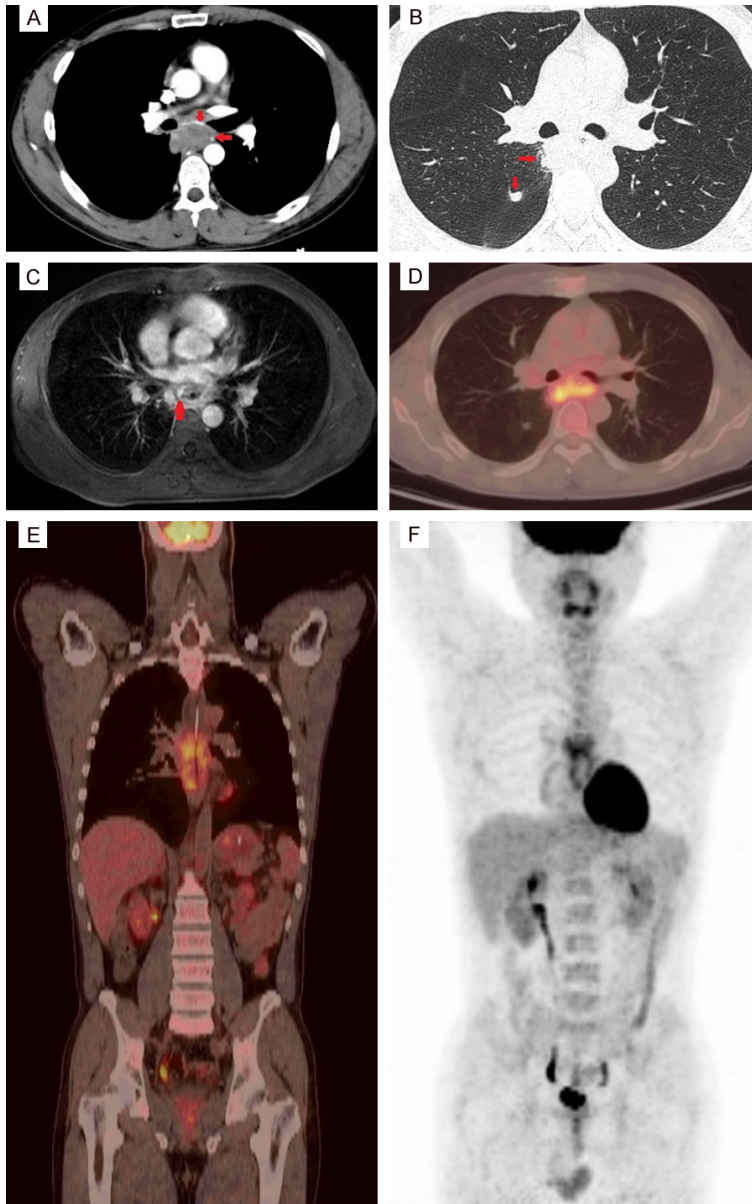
Imaging findings of the patient. A. CT scan confirmed the presence of periesophagus soft tissue, with several bronchial arteries, which was inhomogeneously contrast-enhanced. B. Axial high-resolution CT scan revealed a lesion invading the right mediastinal pleura, and a solid nodule on the oblique fissure pleura. C. The lesion exhibited a widespread slightly high signal and non-enhanced ring line-like low signal on the gadolinium-enhanced LAVA sequence of the MRI scan. D, E. Periesophagus soft tissue (measuring 11.6 cm in length, SUVmax of 4.9) demonstrated avidity on axial and coronal ^{18}F -FDG PET/CT fusion image. Conversely, a solid nodule on the right oblique fissure pleura, exhibited no avidity. F. Maximum intensity projection FDG PET/CT image demonstrated abnormal FDG-avidity in the mediastinal region, but no involvement of the bone or other organs.
